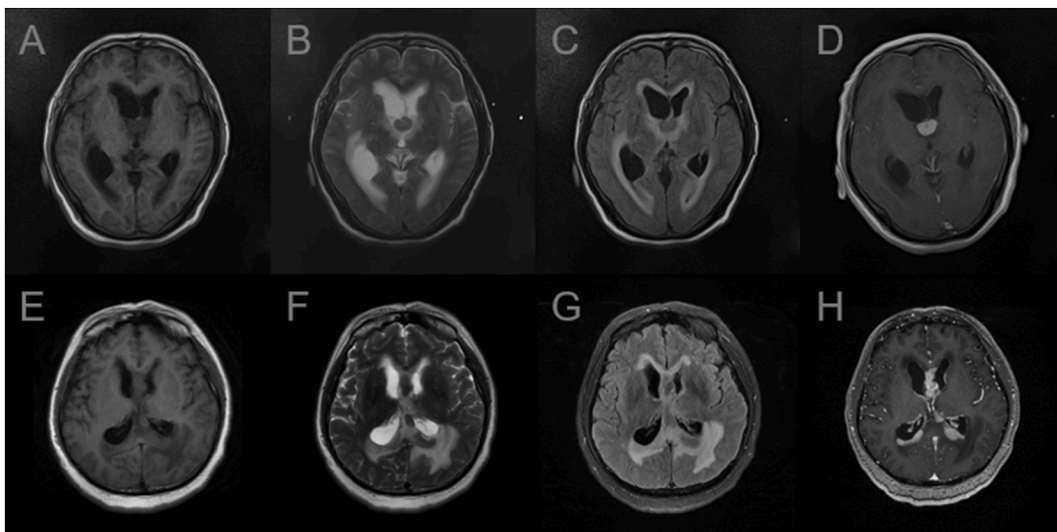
A–D: Case 7, MRI plain scan shows a space-occupying lesion in the third ventricle with a slightly low signal on T1WI and focal hyperintensity on T2WI and FLAIR, while contrast-enhanced scan shows uniform enhancement. E–H: Case 11, MRI plain scan shows space-occupying lesions in both lateral and third ventricles with low signals on T1WI and focal hyperintensity on T2WI and FLAIR, while contrast-enhanced scan shows nodular, clump enhancement.
